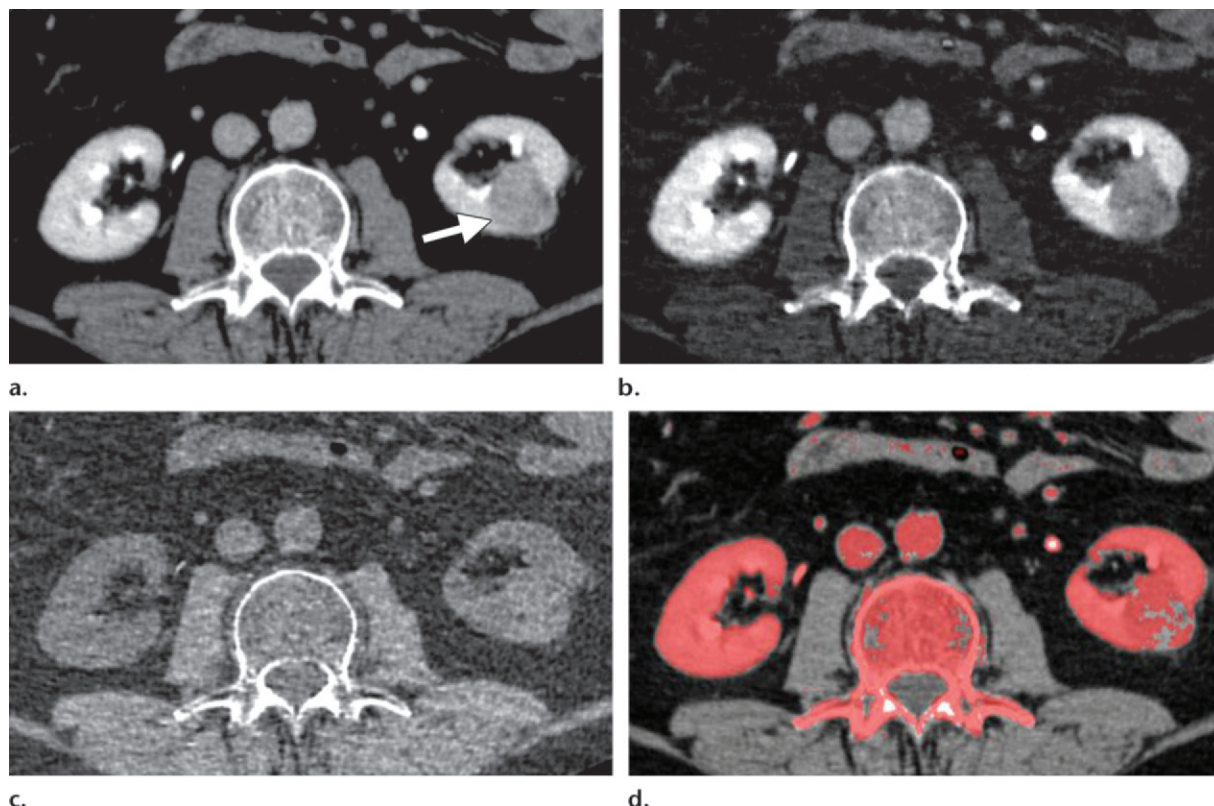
Soft-tissue mass. (a) Axial monochromatic 75-keV image from contrast-enhanced dual-energy CT shows a 3-cm heterogeneous left renal lesion (arrow). (b) Iodine-density image from an iodine-water material-density image pair obtained from the same dual-energy CT dataset as in a shows focal areas of increased brightness representing enhancement interspersed with darker areas in the lesion. (c) Water-density image from the same material-density image pair shows that the areas of the lesion that appear brighter in b are slightly hyperdense relative to the adjacent renal parenchyma, a finding indicative of soft tissue. (d) Color-coded iodine overlay image shows large iodine-containing regions (red pixels) within the lesion, findings suggestive of an enhancing solid mass.
